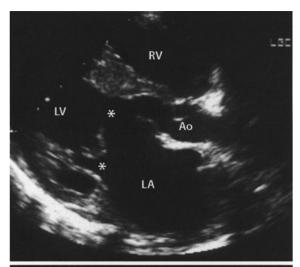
Mitral valve disease: echocardiography. a Parasternal long-axis view showing a double orifice (large and small white asterisks) mitral valve, b parasternal short-axis view of the same patient showing a double orifice (large and small white asterisks) mitral valve (photographs courtesy of Dr. Michael Rigby)
